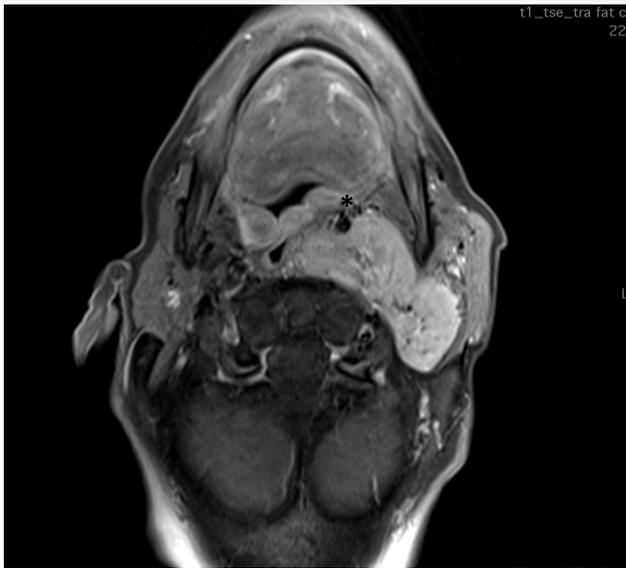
T1 contrasted the MRI axial section of a large VP mimicking a deep lobe parotid tumor (Case 3). The lesion originates from the poststiloiloid part of the parapharyngeal space, note the anterior displacement of the internal carotid artery (asterix). The patient presented with dyspnea and swallowing difficulties due to the oropharyngeal mass effect of the tumor.
